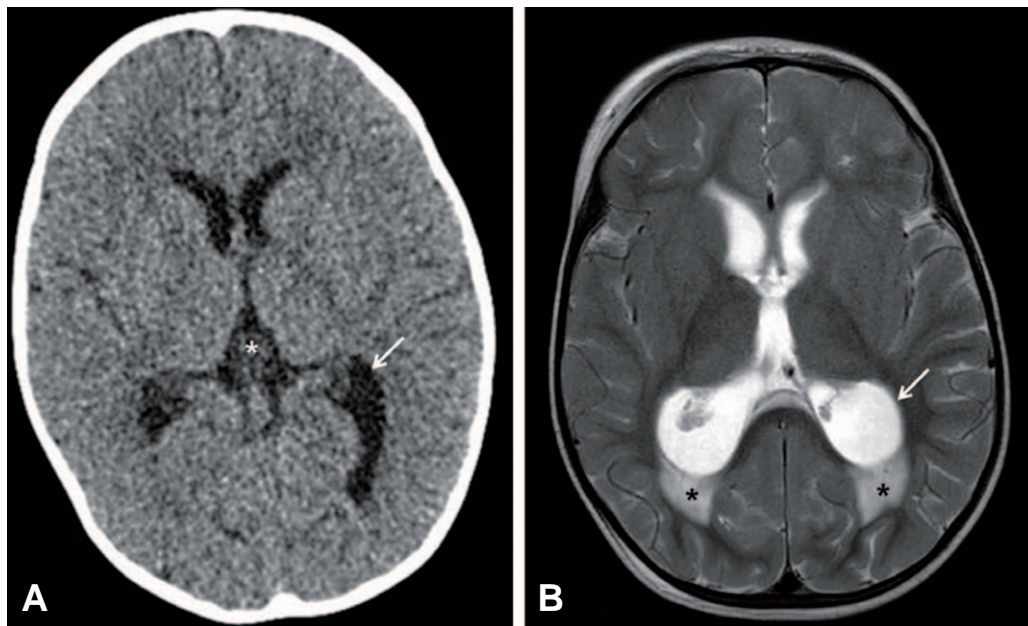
Rapid progression of hydrocephalus due to *Listeria* meningitis. Computed tomography scan on day 1 shows asymmetry of the occipital horn of the left lateral ventricle (arrow, A) and dilated third ventricle (asterisk, A). T2 fluid-attenuated inversion recovery magnetic resonance imaging on day 3 shows both lateral and third ventricles enlarged, particularly the occipital horns (arrow, B). There is also diffuse periventricular edema just posterior to the horns (asterisks, B).
